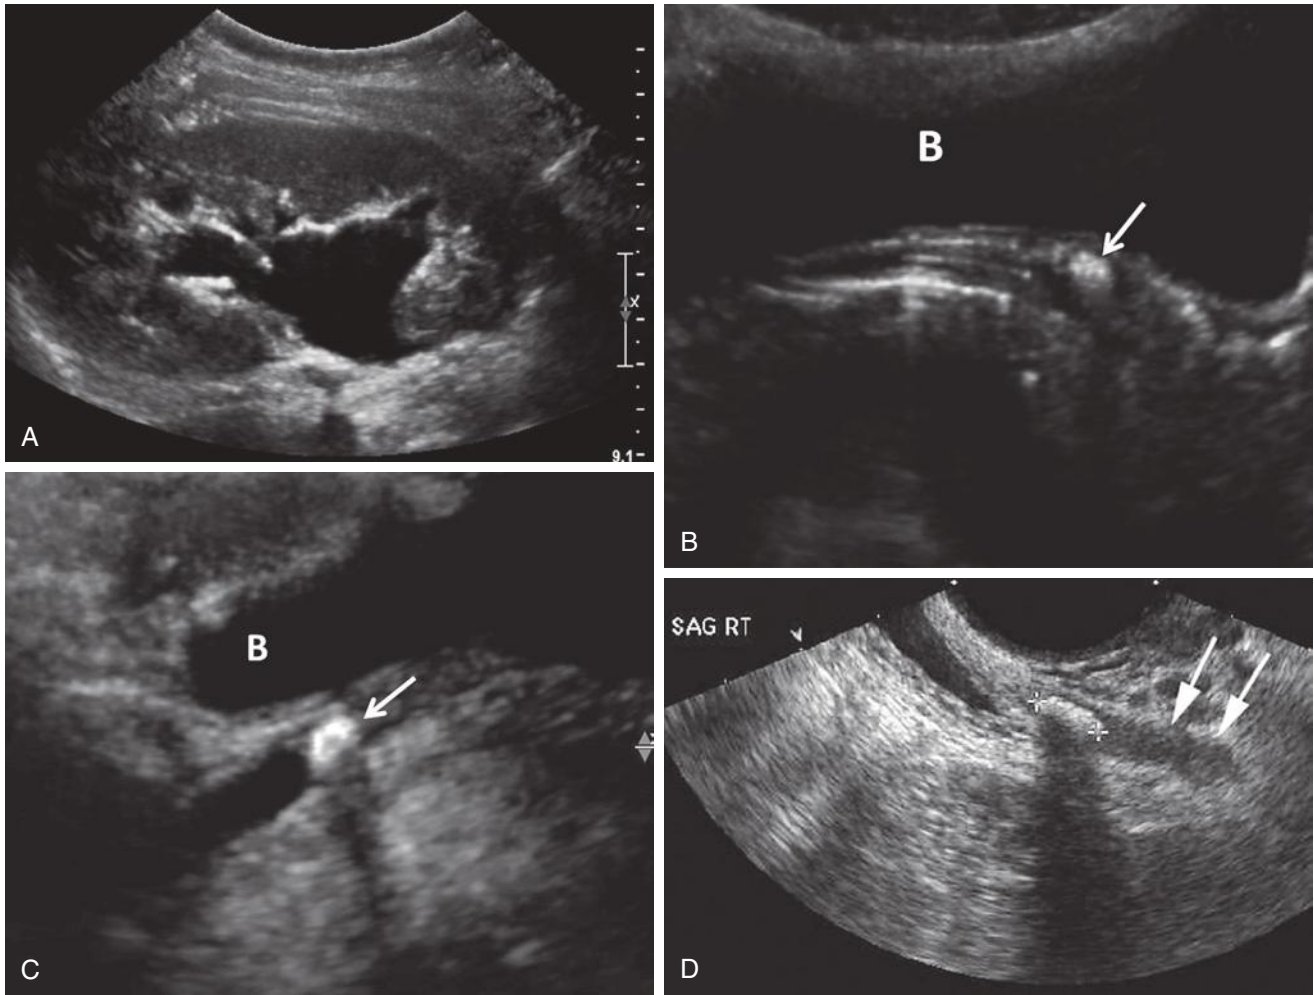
Distal ureteral calculus. A, Longitudinal image of the left kidney demonstrates moderate hydronephrosis. B, Transverse transabdominal sonogram (TAS) of the urinary bladder shows an echogenic calculus (*arrow*) in the distal left ureter at the ureterovesicular junction (UVJ) posterior to the bladder (B). C, Longitudinal TAS shows the distal left ureteral calculus (*arrow*) with posterior acoustic shadowing. The distal left ureter is dilated proximal to the calculus. Note how the distal ureter courses ventrally to enter the bladder (B). D, Longitudinal transvaginal image in a different patient shows an obstructing ureteral calculus (*calipers*) at the UVJ that was not evident on TAS. Note the obstructed, dilated ureter (*arrows*) proximal to the echogenic shadowing calculus.
